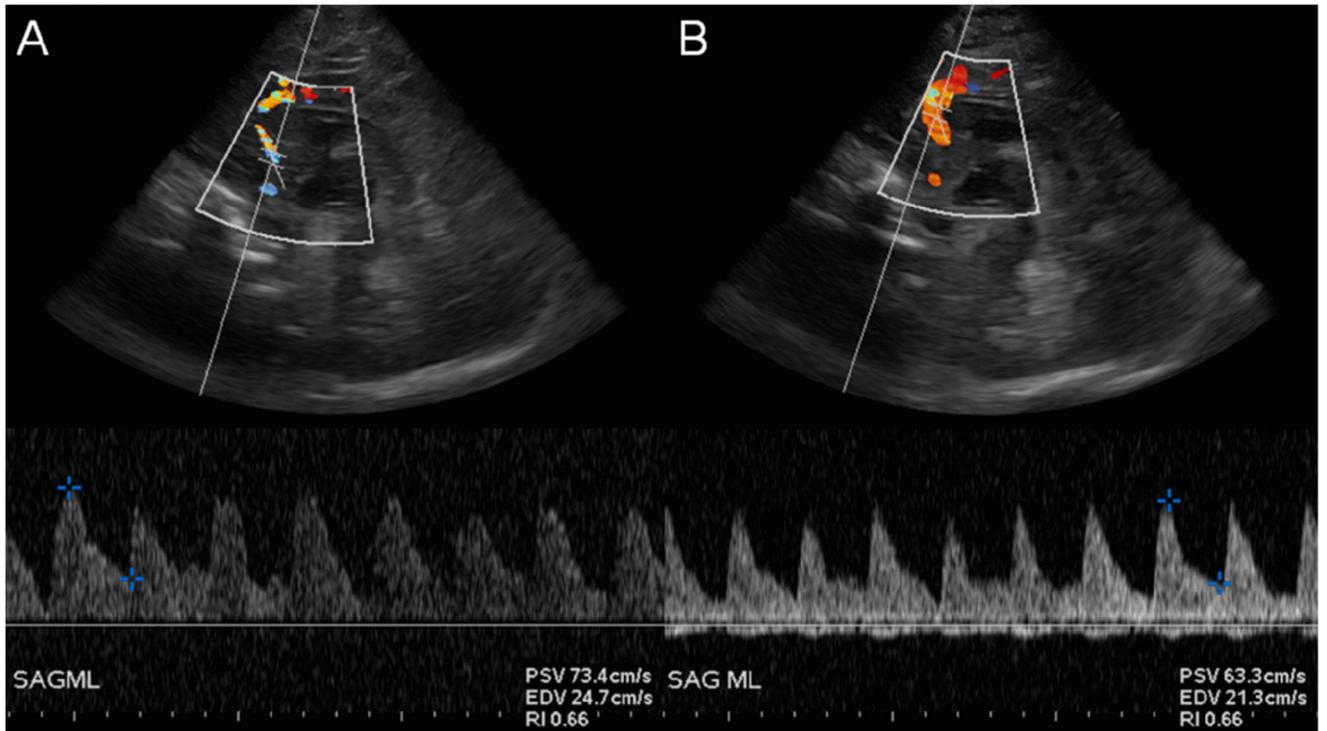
(A) Pre- and (B) post-cooling transfontanellar duplex head ultrasound with measurement of RI values within the anterior cerebral artery in a neonate after HIE; pre- and post-cooling RI values are 0.66, respectively.
